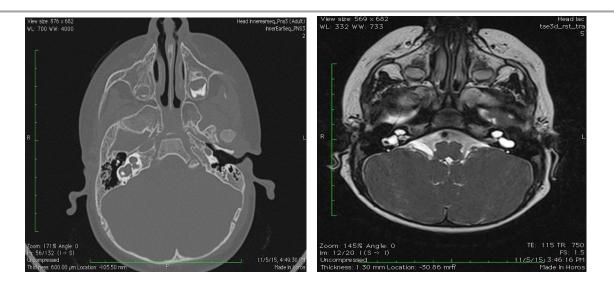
Left panel, CT scan of temporal bone, axial section, showing right-sided incomplete partition type 1 Right panel, MRI axial section T2-weighted image showing bilateral incomplete partition type 1
